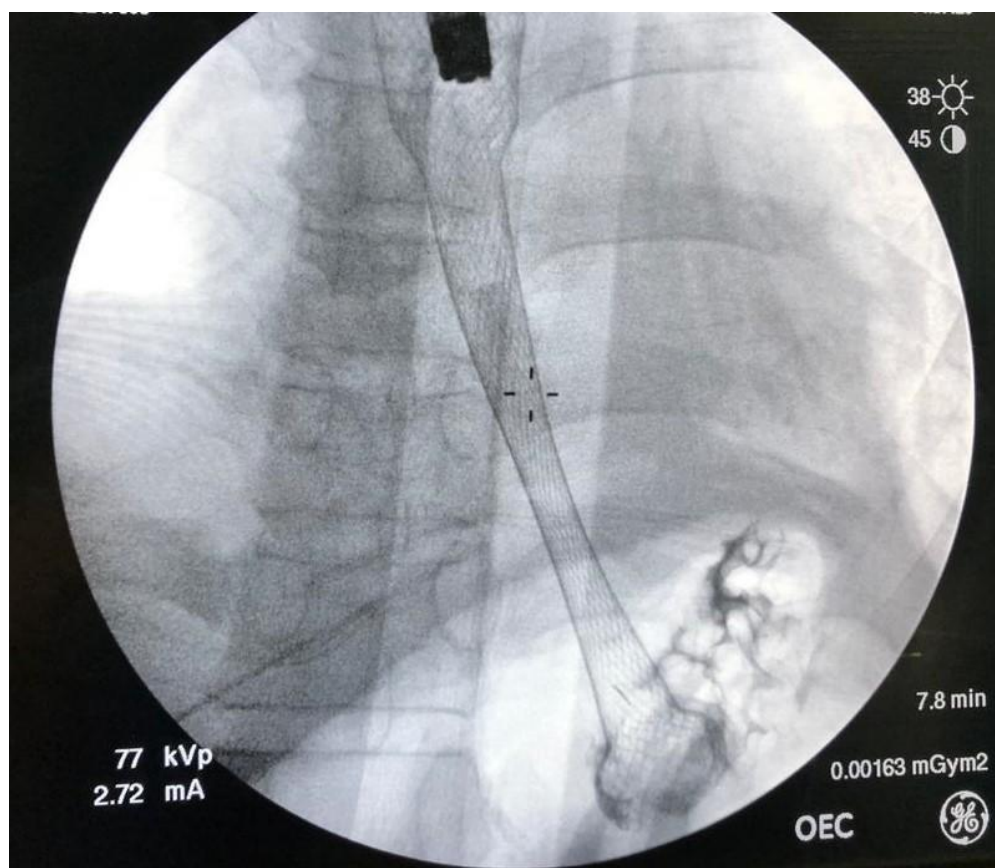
The position of FCSEMS confirmed by plain radiograph
